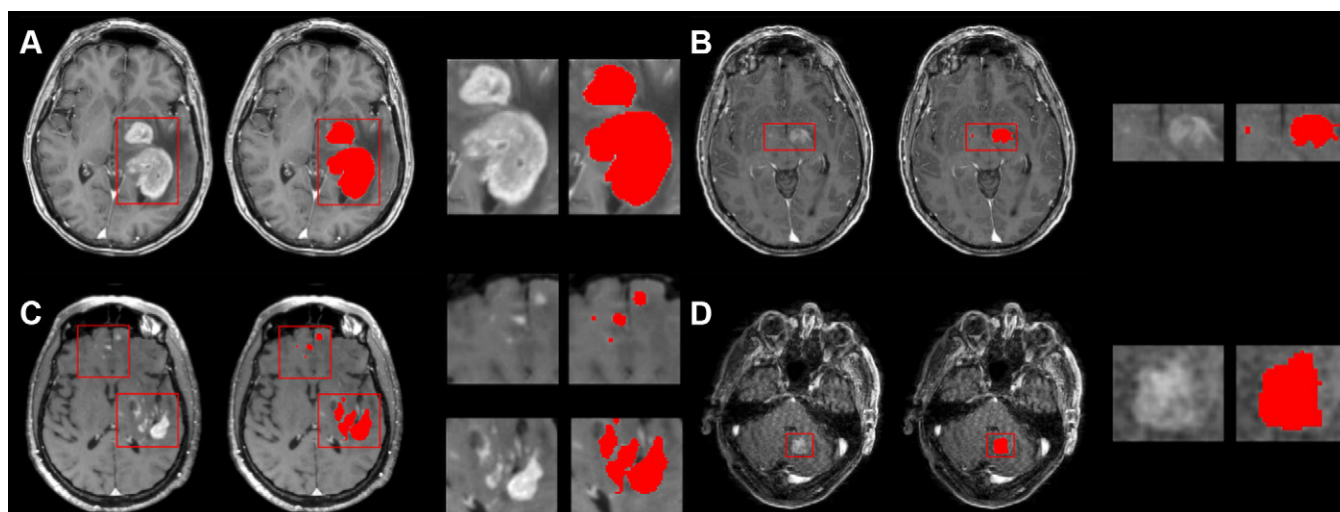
Gadolinium T1-weighted contrast-enhanced MRI scans acquired in clinical practice for patients with primary central nervous system lymphoma. For each of four patients (A–D), an image on an axial plane is shown, followed by the same image overlaid with the annotated segmentation, and a zoom-in of the area(s) marked with a box.
